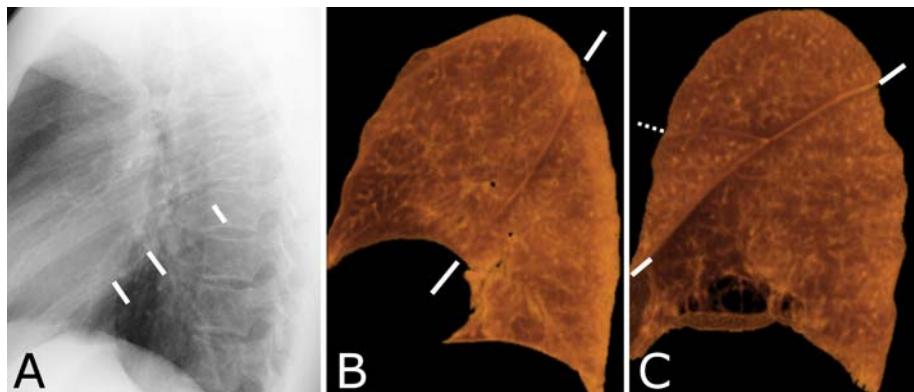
Lungs. A. Lateral radiograph shows the major fissures (white lines). The lower lobes sit below this fissure, while the upper (and on the right middle) lobes sit anterior to this fissure. B (left lung) and C (right lung) volume rendered CT images to show the course of the major fissures (white lines) as seen on a lateral chest radiograph. Note that in the right lung the minor fissure is also identified (white dotted line).
